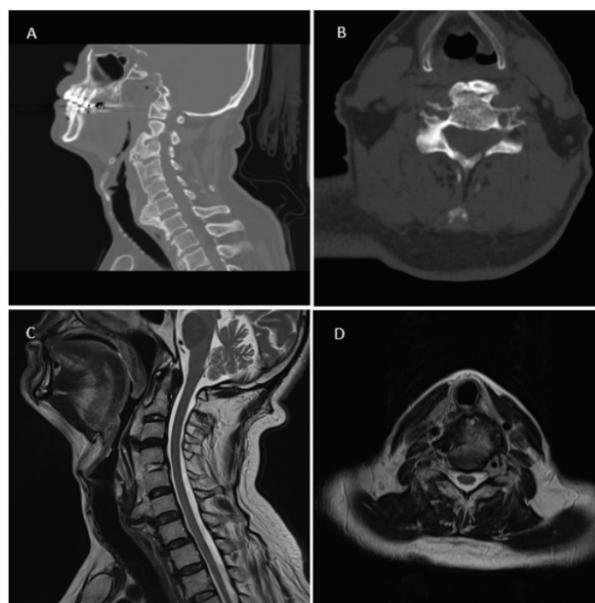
Preoperative CT (A, B) and MRI (C, D) scans of a patient with DISH presented with dysphagia
